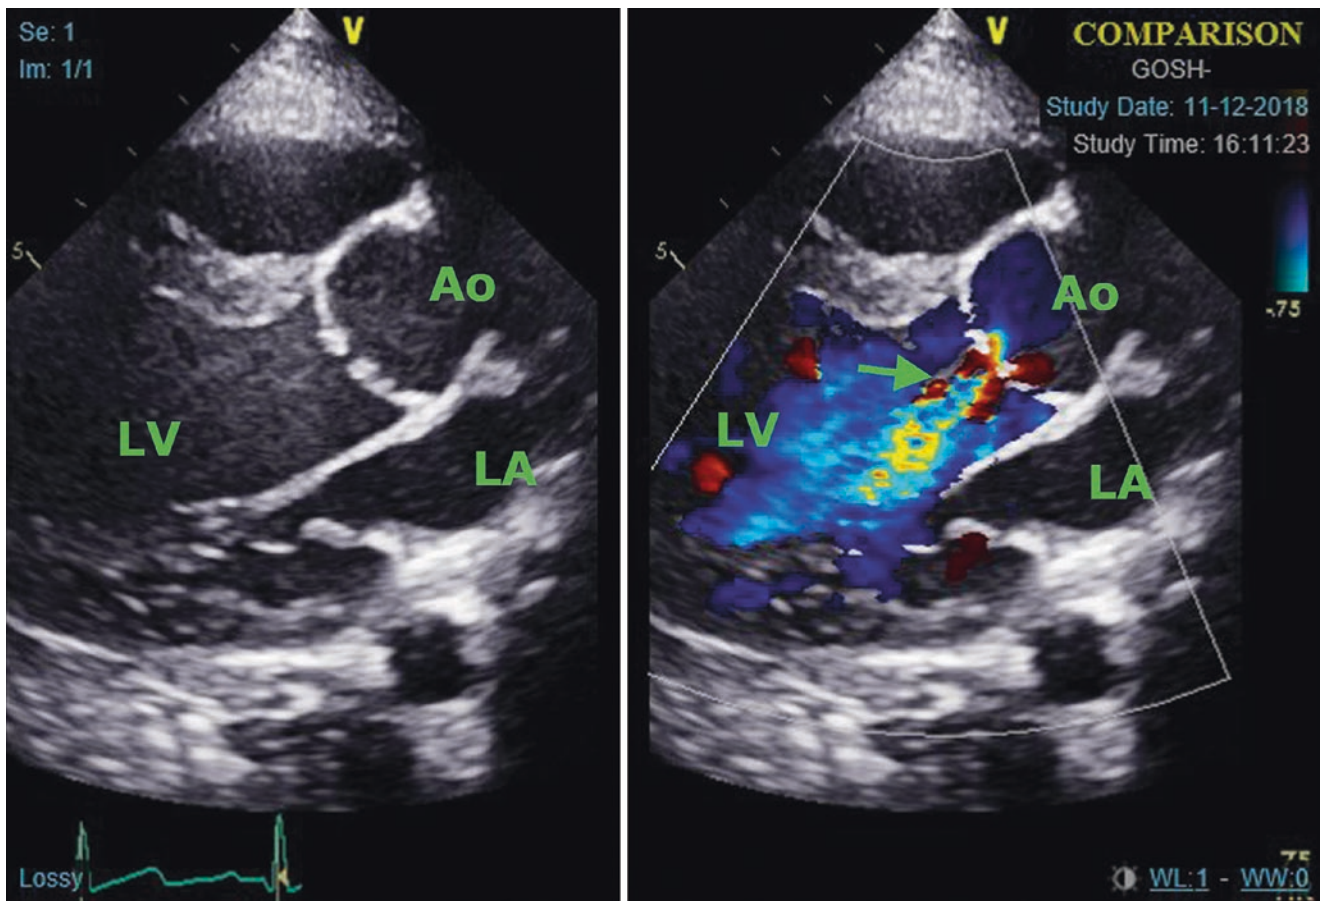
Echocardiographic finding from a patient with Morquio syndrome with aortic valve involvement and aortic regurgitation (arrow) (courtesy J. Marek, Great Ormond Street Hospital, London, UK)
